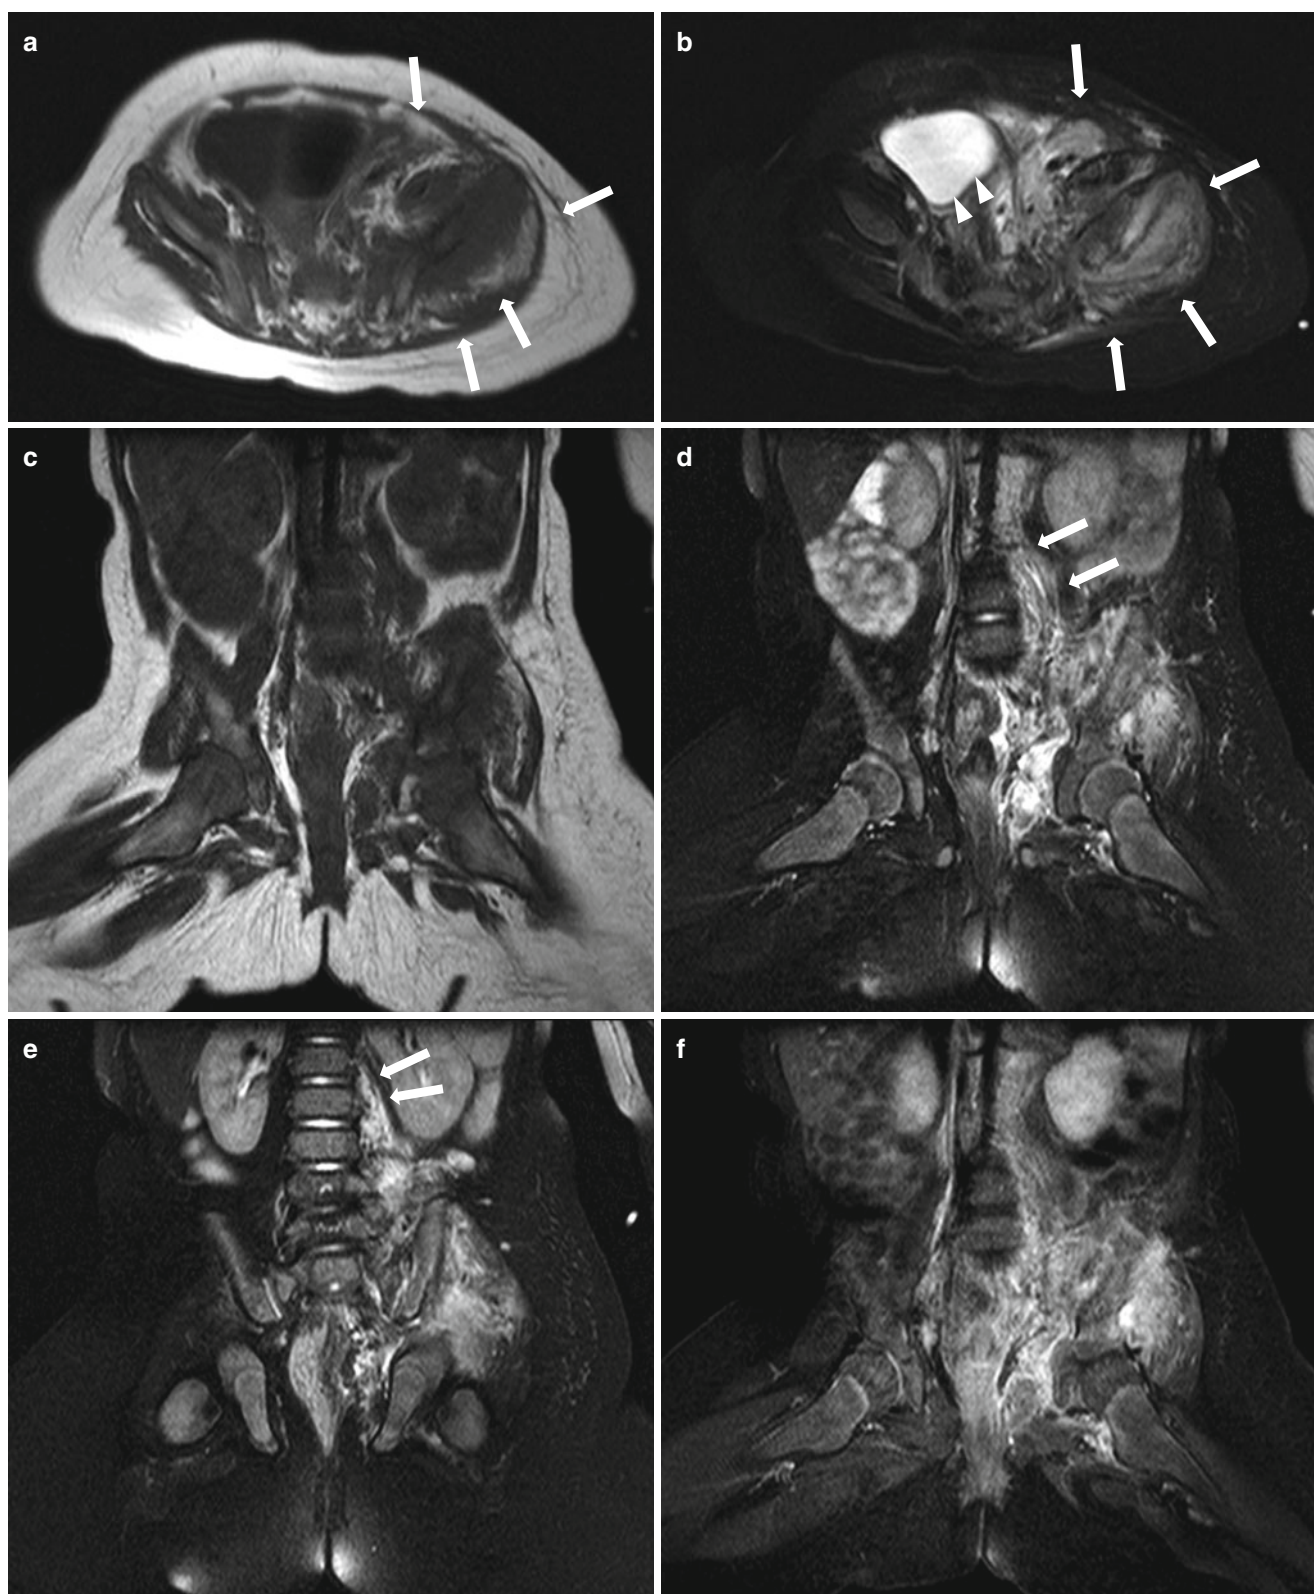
Angiosarcoma in pelvis of a 5-month-old boy. (a) Axial T1-weighted MR image shows isointense soft tissue mass (*arrows*) relative to muscle involving Lt. pelvis with iliac bone destruction. (b) Axial fat-suppressed T2-weighted MR image shows the ill-defined infiltrative mass (*arrows*) with heterogeneous high signal intensity. Urinary bladder is compressed by the mass (*arrowheads*). (c, d, e)
